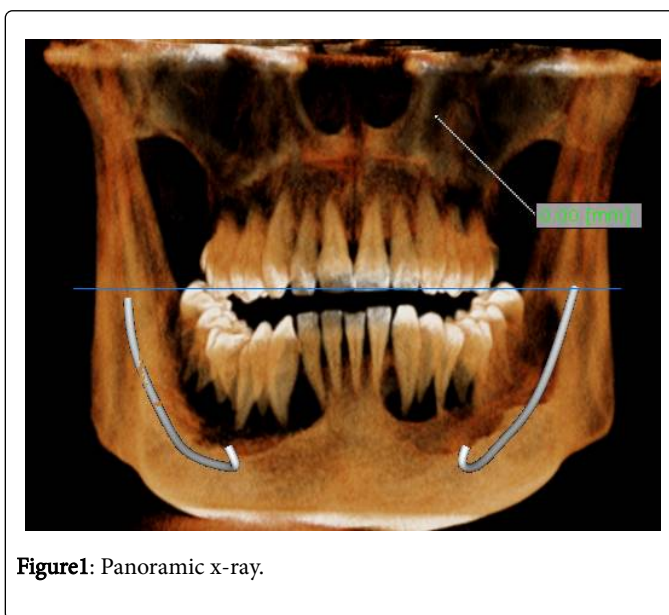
Panoramic x-ray.
